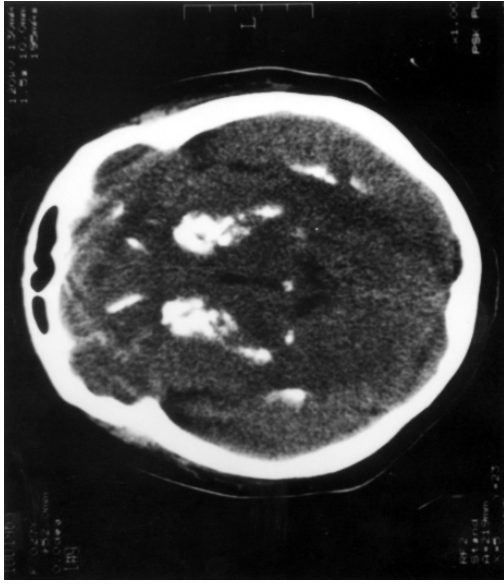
CT indicating extensive bilateral symmetrical calcifications in the basal ganglia, thalamus and cerebellum
